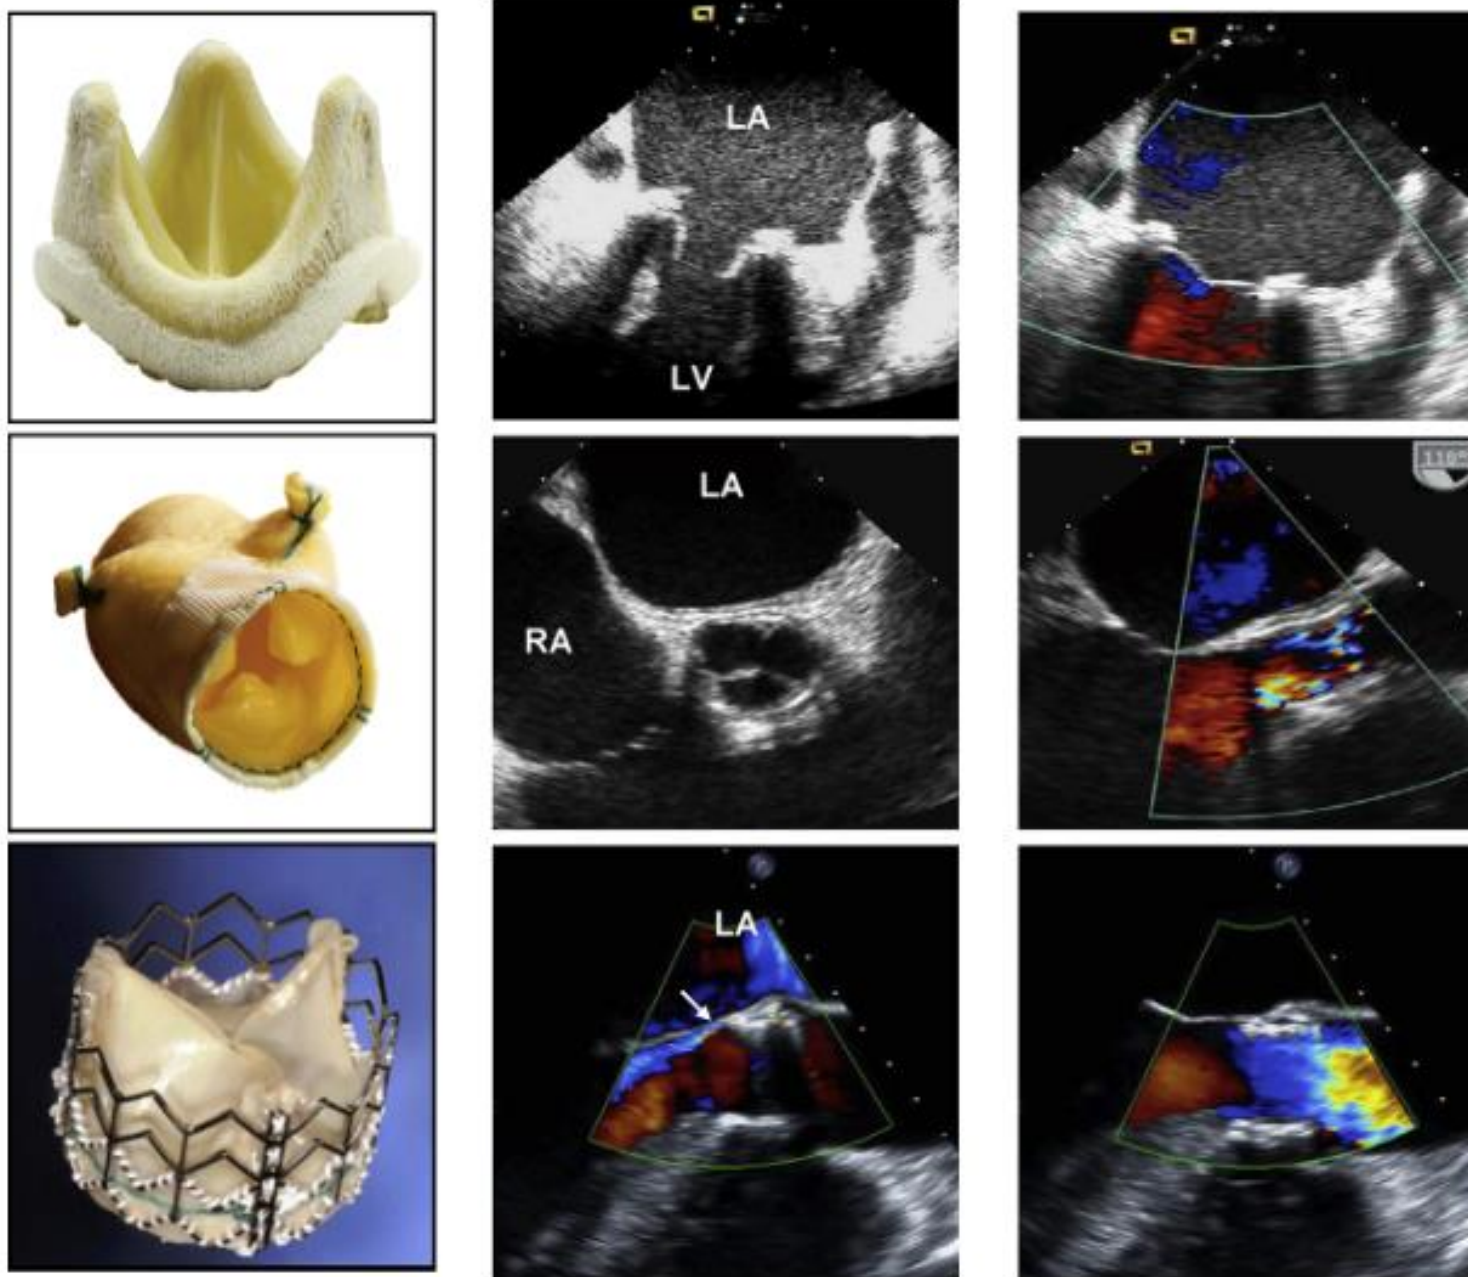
Examples of stented, stentless, and percutaneous biologic valves and their echocardiographic features in diastole (*middle*) and in systole (*right*) as seen by TEE. The stentless valve is inserted by the root inclusion technique. Mild perivalvular AR in the percutaneous valve is shown by *arrow*. The percutaneous biologic valve is currently for investigational use only. Videos 7 to 10 show the valve motion and color Doppler flow pattern of these valves.  View video clips online.
